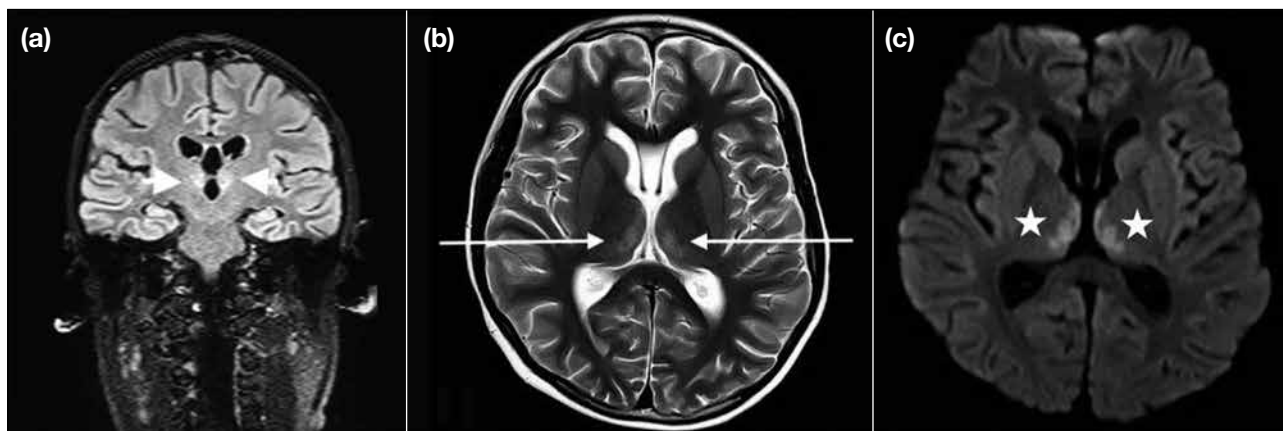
Magnetic resonance imaging in case 1. (a) Fluid-attenuated inversion recovery and (b) T2-weighted sequences showing symmetrical T2 hyperintensity in bilateral thalami (arrows). (c) Diffusion-weighted imaging showing corresponding restricted diffusion (stars).
